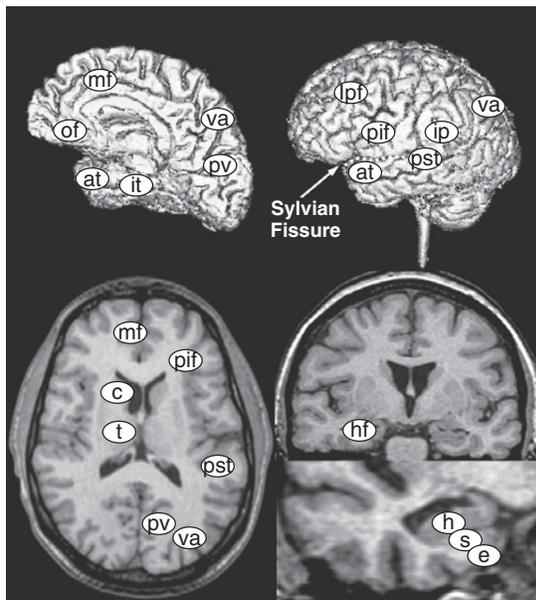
Magnetic resonance images of a normal brain. Upper left, Midsagittal view; upper right, left lateral view; lower left, axial view through the head of the caudate and body of the thalamus; lower right, coronal view through the mammillary bodies, with a magnified view of the medial temporal lobe. at = anterior temporal; c = caudate nucleus; e = entorhinal cortex; h = hippocampus; hf = hippocampal formation; ip = inferior parietal cortex; it = inferior temporal; lpf = lateral prefrontal cortex; mf = medial frontal cortex; of = orbital frontal cortex; pif = posterior inferior frontal cortex (Broca's area); pst = posterior superior temporal; pv = primary visual cortex (area 17); s = subiculum; t = temporal; va = visual association cortex (areas 18 and 19). (Courtesy Maria Shiung and Clifford Jack, MD.)
